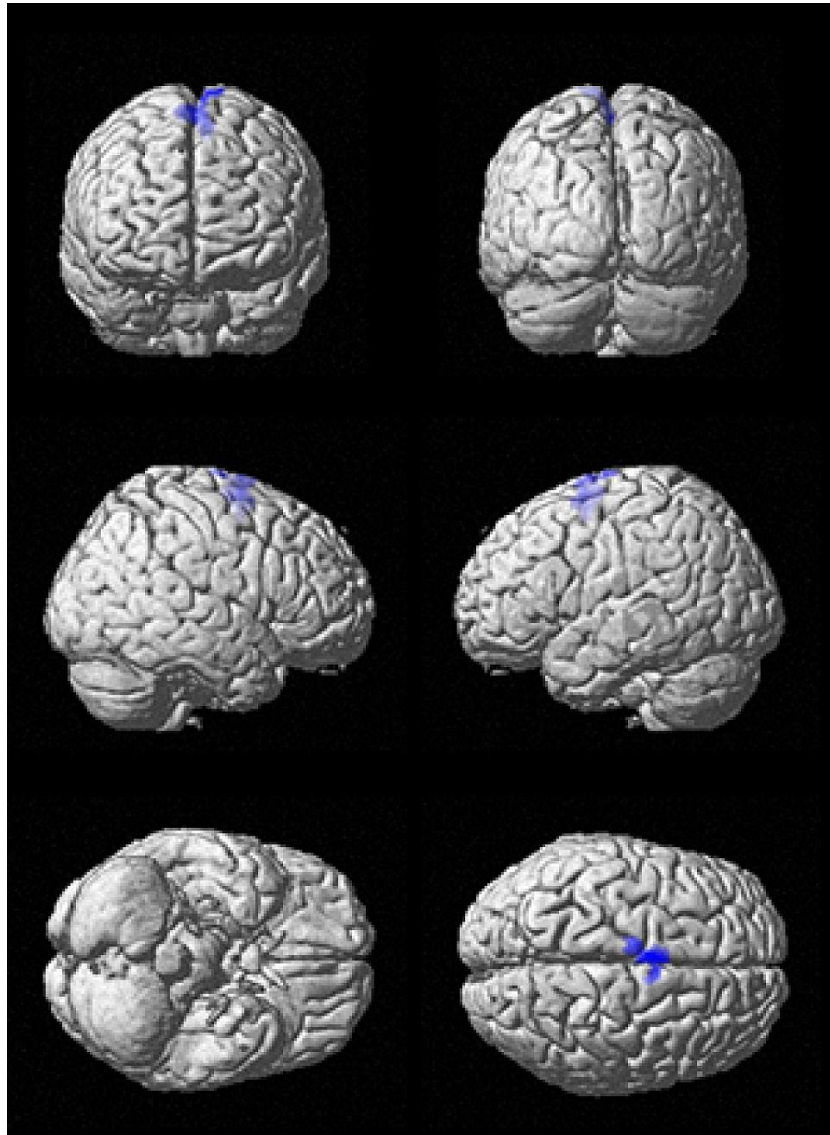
The Shaded Areas Were Activated by Familiar Music. In the same study detailed previously, Jace King, a graduate student in the Brain Networking Lab says, “Music is like an anchor, grounding the patient back in reality.” These images were taken using a functional MRI, where researchers scanned the patients to image the various regions of the brain that lit up when the patients listened to twenty-second clips of music, as opposed to silence. The researchers played eight clips of music from the patient’s music collection, followed by eight more clips of the same music played in reverse and eight blocks of silence. Source: (University of Utah Health, 2018)
